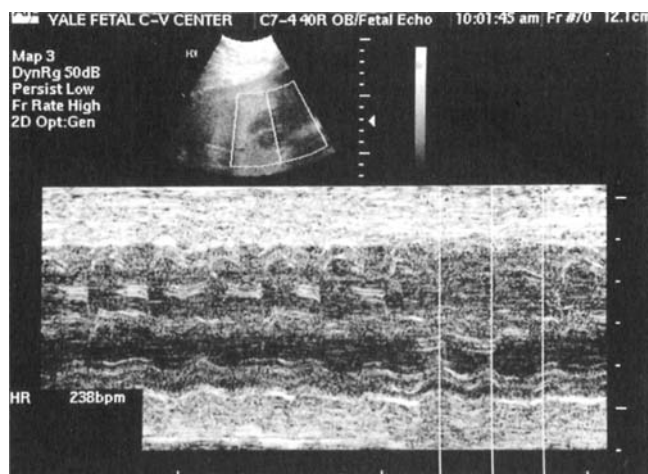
M-mode echocardiogram demonstrating a rapid atrial rate of 238 bpm secondary to SVT. The M-mode cursor is at the level of the atria.
